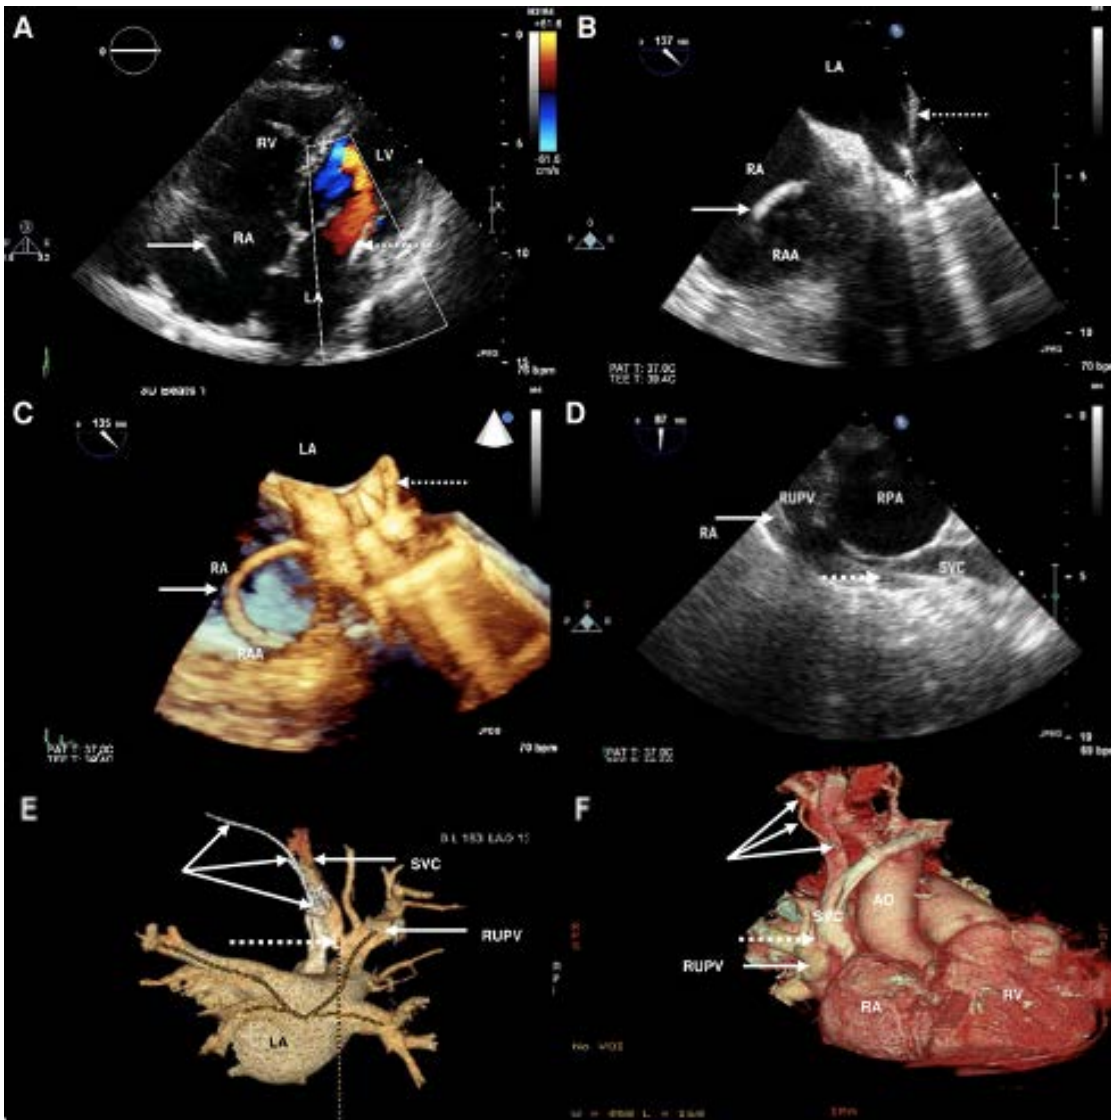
A. Echocardiography — TTE 2D modified 4C: visible one lead in RA (solid arrow) and other lead penetrating from LA to LV through the mitral valve (dashed arrow). B. Echocardiography — TEE 2D: visible one lead in RA (solid arrow) and other in LA (dashed arrow). C. Echocardiography — TEE 3D: visible one lead in RA (solid arrow) and other in LA (dashed arrow). D. Echocardiography — TEE 2D: visible lead in SVC (dashed arrow) and in RUPV (solid arrow). E. Cardiac tomography — MSCT VRR: visible lead (triple solid arrows) and anomalous connection of RUPV to SVC size 8.5×7.0 mm (dashed arrow). F. Cardiac tomography — MSCT VRR: visible lead (triple solid arrows) and anomalous connection of RUPV to SVC size 8.5×7.0 mm (dashed arrow)
